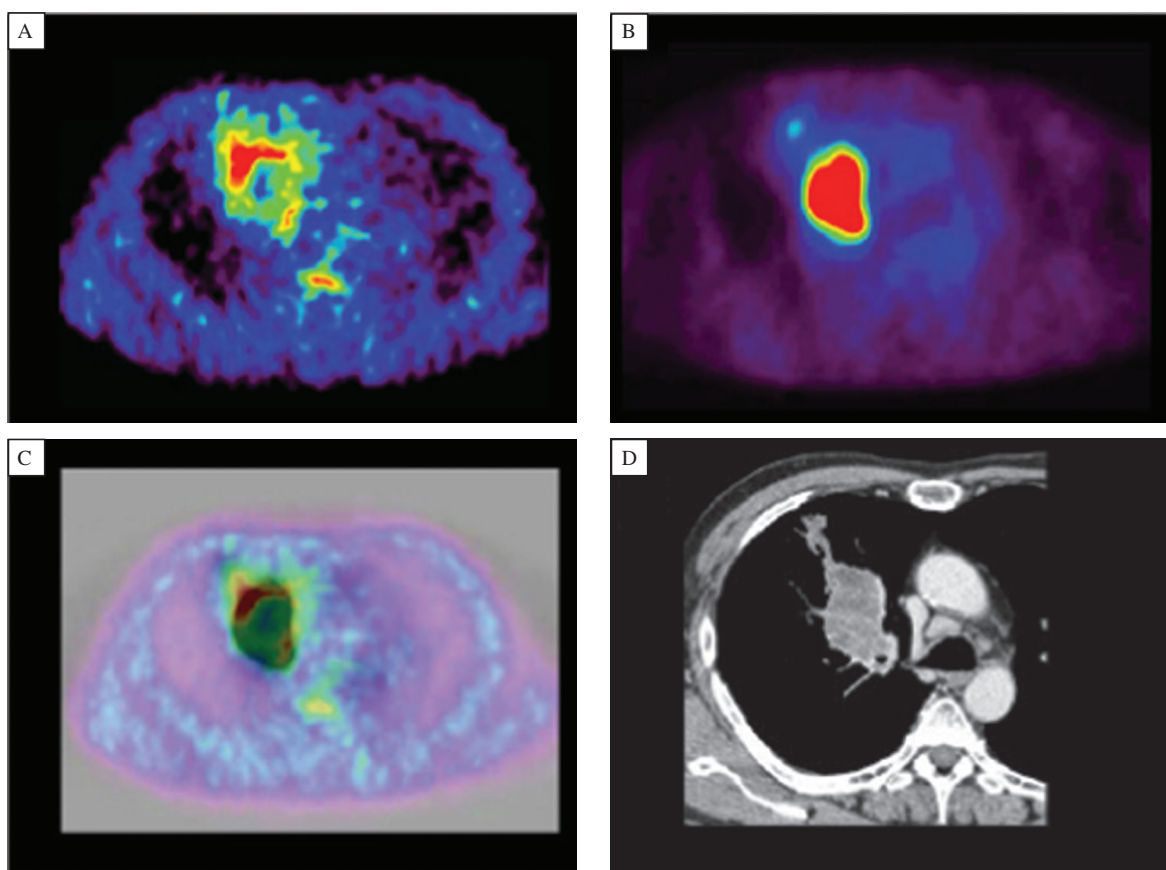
^{62}Cu -ATSM (A) and ^{18}F -FDG PET (B) PET images in a patient with squamous cell carcinoma (SCC) (with permission from reference 39). ^{18}F -FDG image shows intense uptake in the right lung. ^{62}Cu -ATSM image at the corresponding slice level displays high uptake in a region different from the ^{18}F -FDG image. Fusion image (C) is depicted for ^{62}Cu -ATSM PET in color and for ^{18}F -FDG PET in gray scale. CT image (D) at the same level demonstrates soft-tissue density with irregular borders of 53×36 mm adjacent to the right mediastinum.
